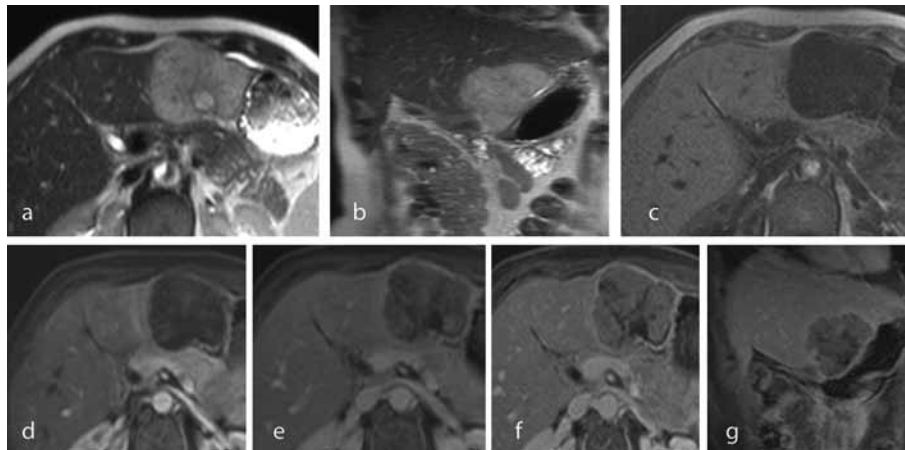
Magnetic resonance imaging examination of the liver at initial diagnosis.
